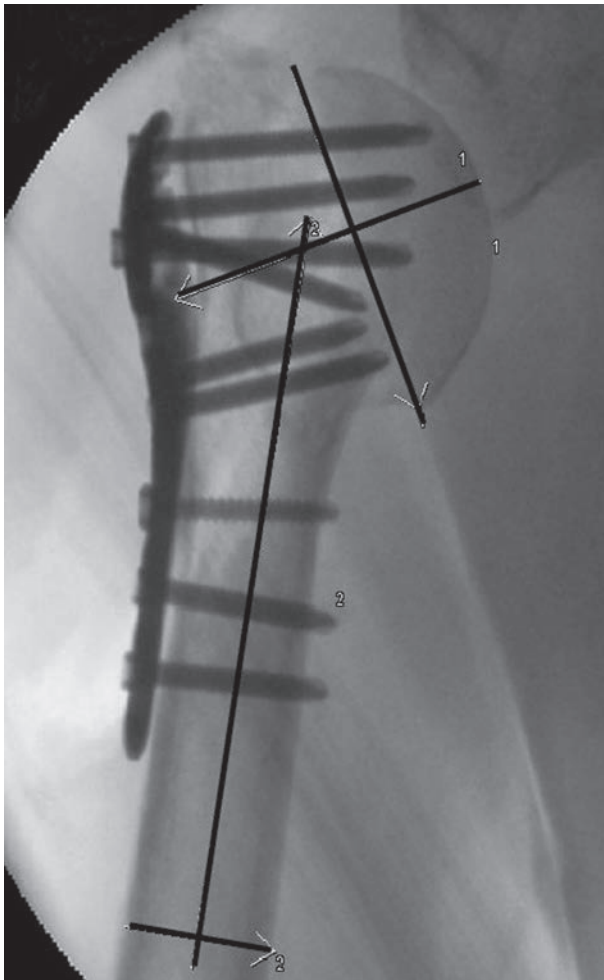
Postoperative radiograph demonstrated fracture reduction in varus ($119,61^\circ$) with the described “P sign”
